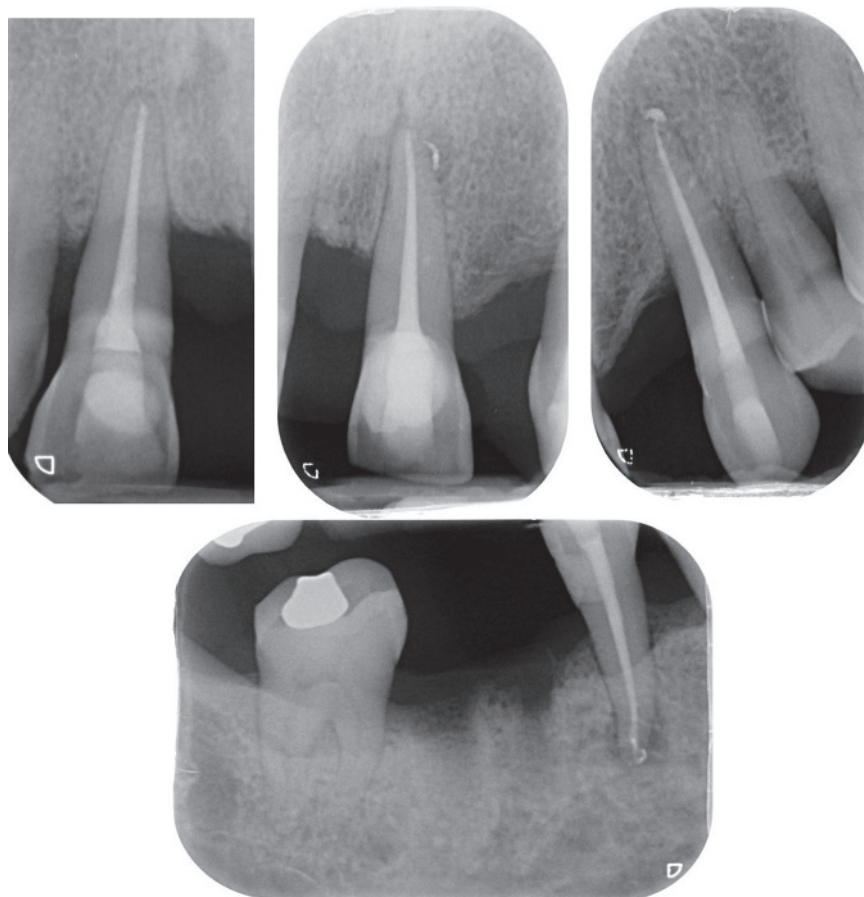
Postoperative periapical radiographs of the teeth following root canal treatment showing evidence of periapical healing.
